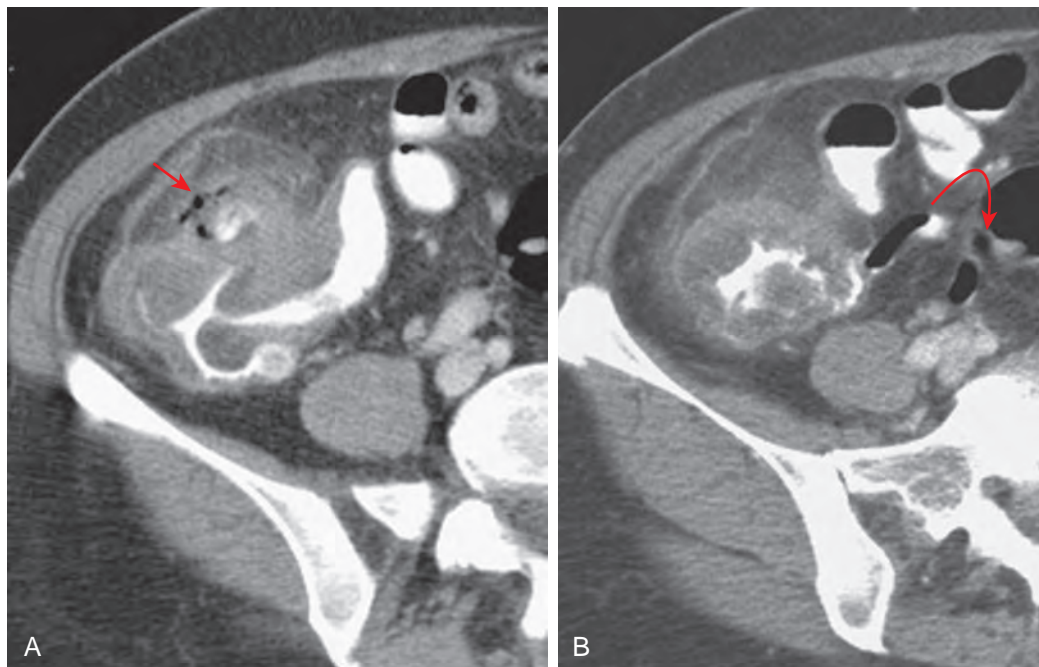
Right-sided diverticulitis. A. This enhanced CT scan shows the inflamed diverticulum (arrow) in the proximal ascending colon with surrounding inflammatory changes and associated reactive lateral colonic wall thickening. B. This slightly more caudal image shows the normal appendix (curved arrow) medial to the inflamed right colon.
